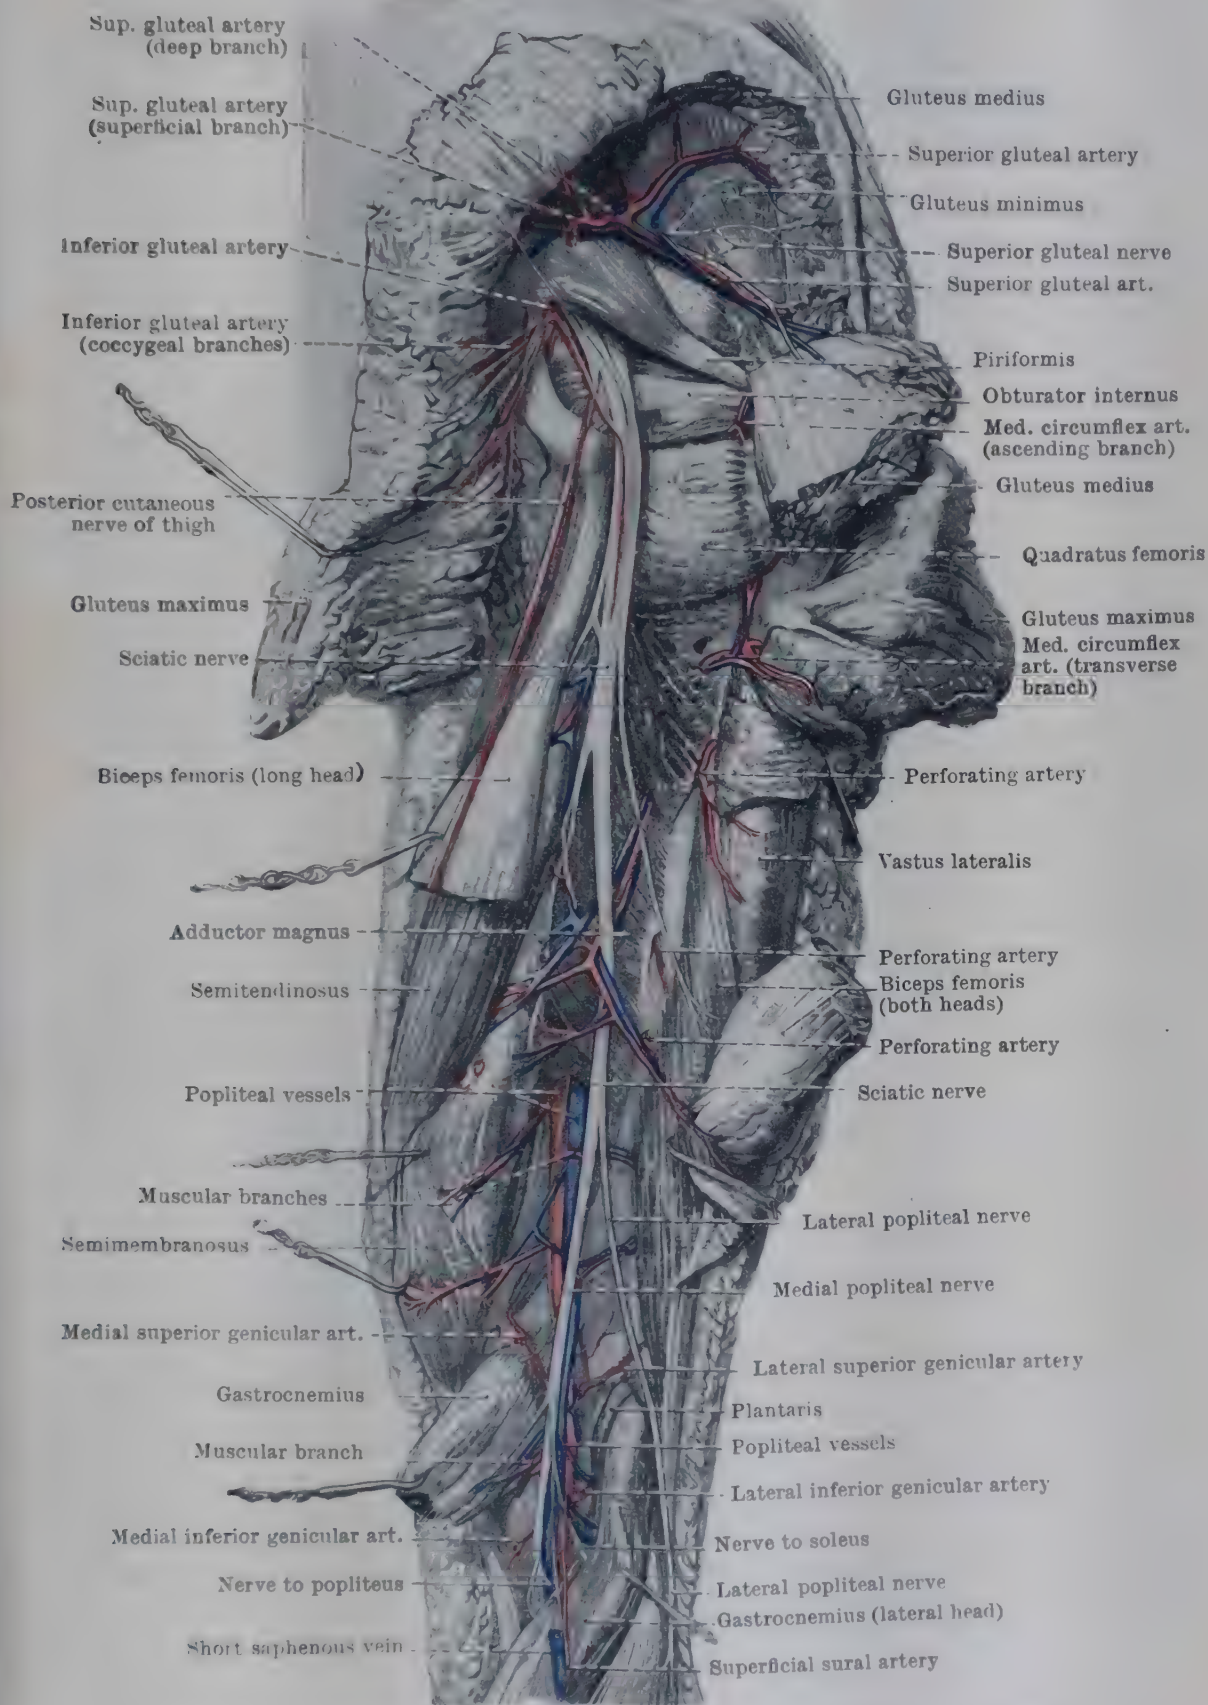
ARTERIES OF BUTTOCK AND POSTERIOR ASPECT OF THIGH AND KNEE.
